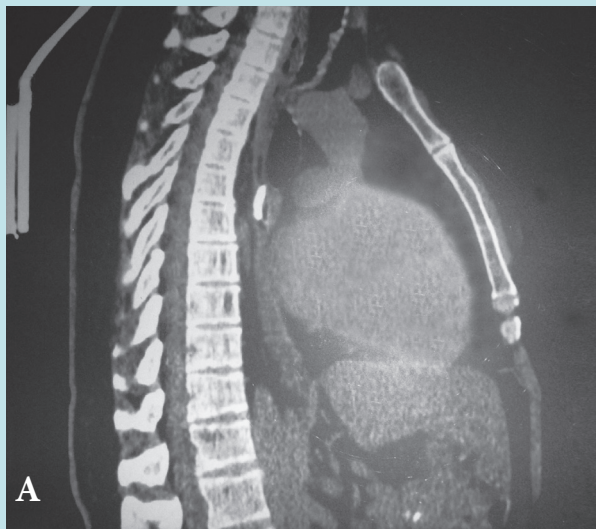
The computed tomography image of a calf bone in the esophagus
